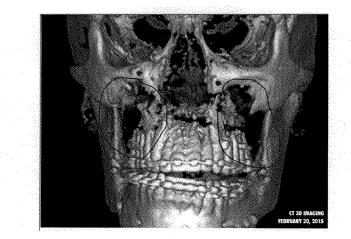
Full Volume Frontal View of Christopher Kevin LaBonte's CBCT scan. Note the holes in the eye sockets from screw and hardware removal. Also note the bone loss due to hardware removal due to poor/inexperienced surgical technique.
